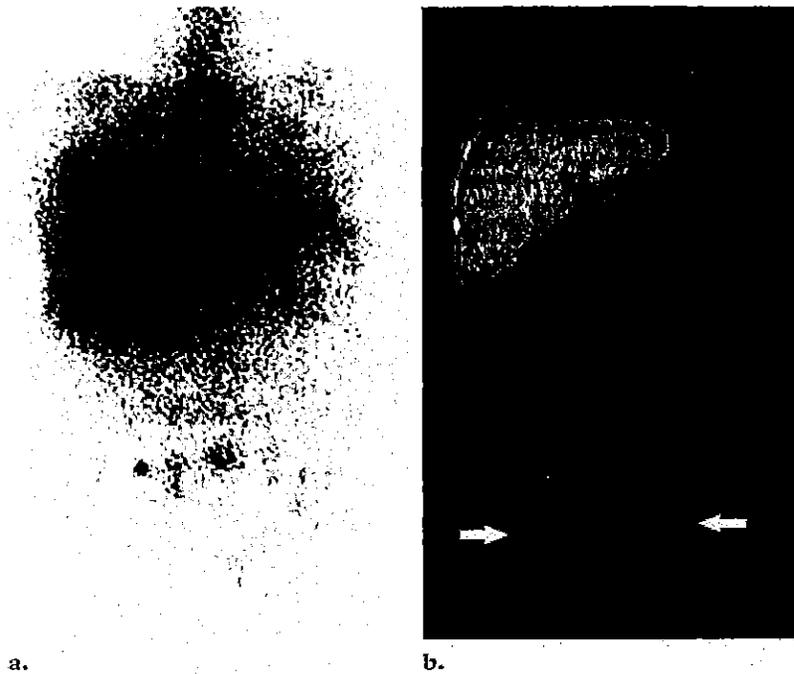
Localization of malignant disease in an elderly man with a history of prostate cancer and an increasing prostate-specific antigen level. (a) Anterior ^{111}In ProstaScint (Cytogen) whole-body scan shows subtle uptake in the pelvis. (b) Fused SPECT/CT image shows probable metastatic disease in bilateral inguinal lymph nodes (arrows).
